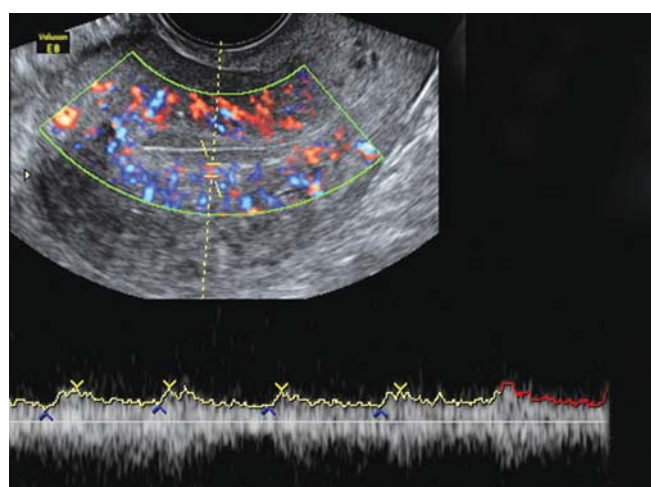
Pulse Doppler of endometrial vascularity
